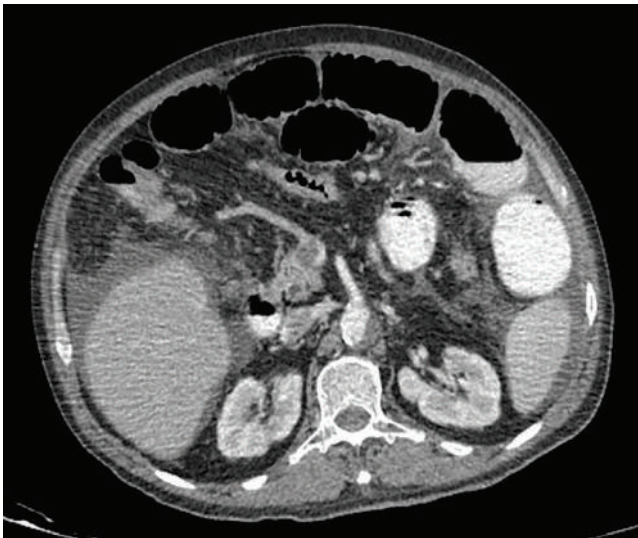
Computed tomography scan: superior mesenteric vein occlusion by thrombus with extension toward the portal vein; associated ileal wall thickening and dilatation.
